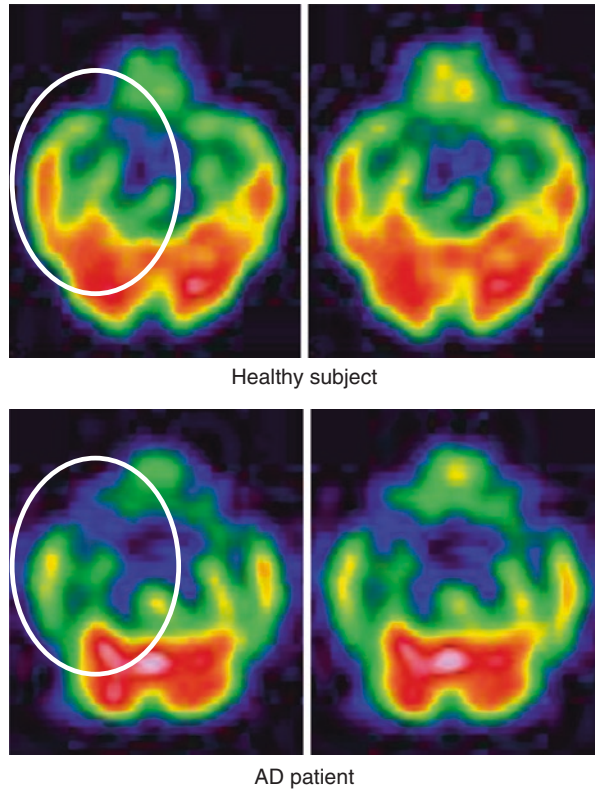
A key to notice hypoperfusion in PCG and precuneus. The *white circle* shows the hypoperfusion in PCG and precuneus. Note the dip in SPECT image shown by white arrow. This dip reflects the hypoperfusion in PCG
